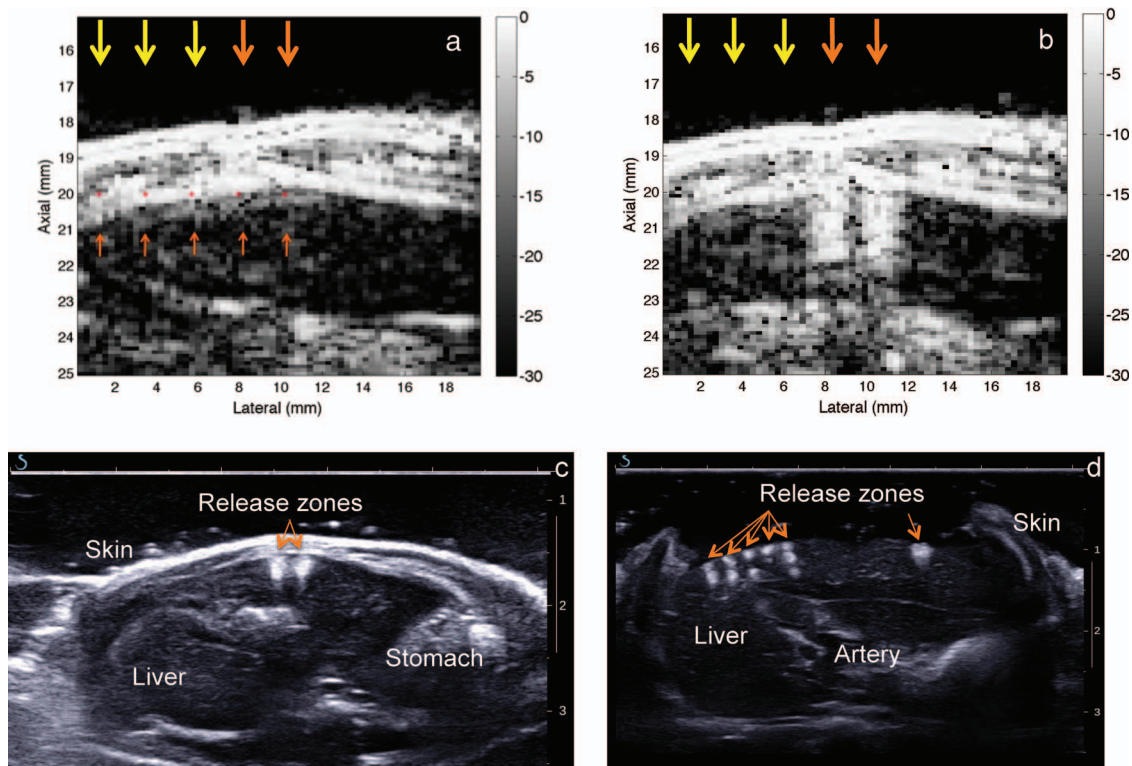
(a) Conventional 5 MHz B-mode of the liver in the region of interest prior to the ultrasound-induced release. The arrows point at the five focal release zones selected by the user directly on the image (from left to right: 1.2 MPa, 2 MPa, 2.6 MPa, 3.5 MPa, and 4.4 MPa peak-negative pressure). (b) Conventional B-mode of the liver after the ultrasound-induced release. In average, the two zones are 25 dB more echogenic with respect to the early image. (c) B-scan over a wider region of the liver with a 8 MHz transducer after the two-points ultrasound-induced release. (d) B-scan of an exposed liver over a five-points release (left of the liver) and a two-points release (right).
